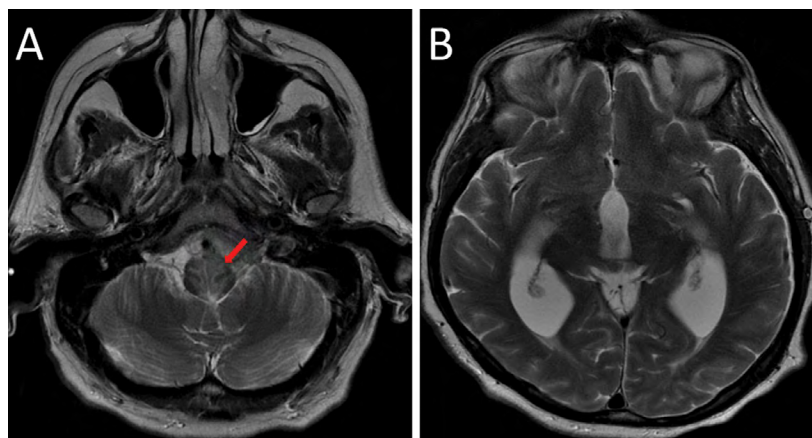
Axial T2-weighted images: (A) shows abnormal signal hyperintensity within the upper medulla, adjacent to the areas of cisternal enhancement; (B) demonstrates hydrocephalus with expansion in the caliber of the third and lateral ventricles
